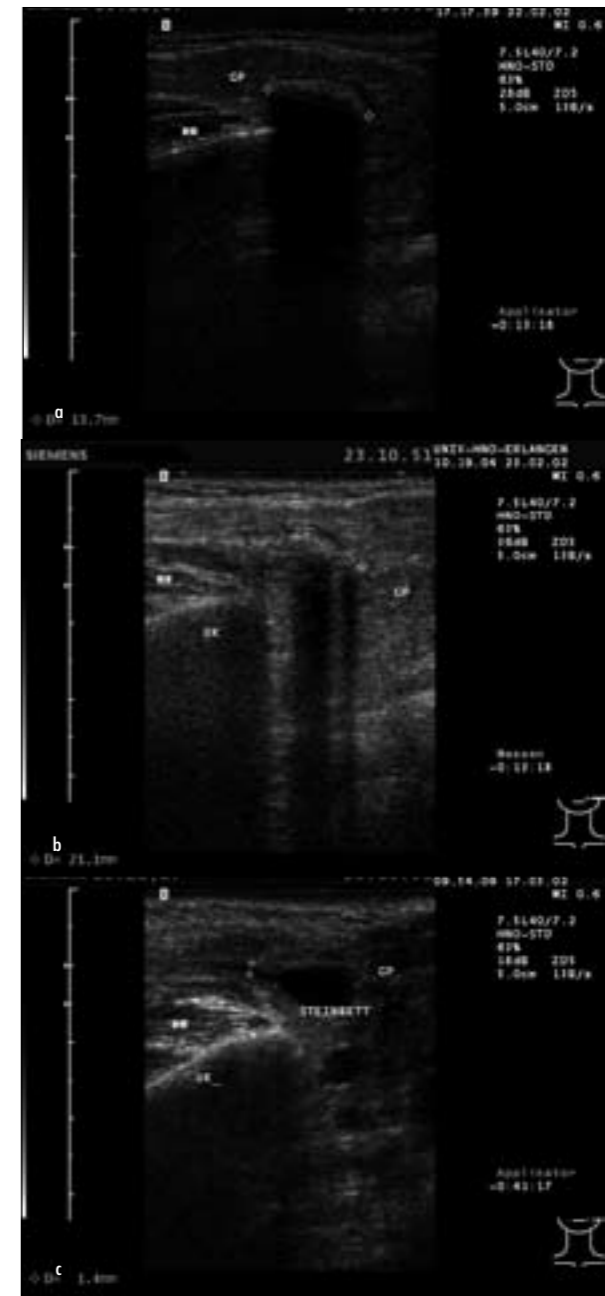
a. Sonographic image of a left parotid stone (+.....+, 28.3 mm in diameter, echogenic reflex with posterior acoustic shadow) before extracorporeal shock wave lithotripsy (ESWL). MM = masseter muscle, UK = mandible, GP = parotid gland. b. Fragmented sialolith 1 day after ESWL. UK = mandible. c. No sialoliths are detectable on the sonographic view of the parotid gland after ESWL. Note the hypochoic region where the sialolith was formerly localized ('Steinbett').
